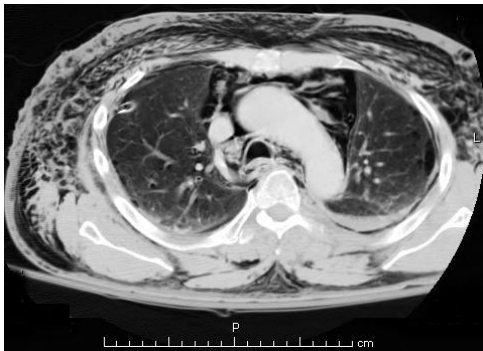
CT image. Left pneumothorax, pneumomediastinum and subcutaneous emphysema.
